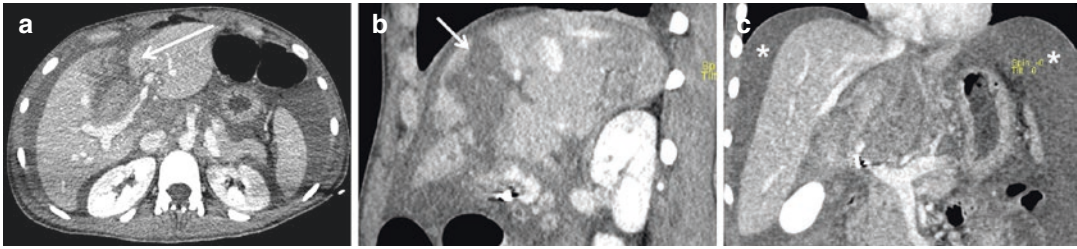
(a) Axial CT scan, (b) coronal, and (c) sagittal reconstruction show a deep hepatic laceration >3 cm deep (arrows in a) and (b). In (c), a huge hemoperitoneum is appreciable (asterisks)
